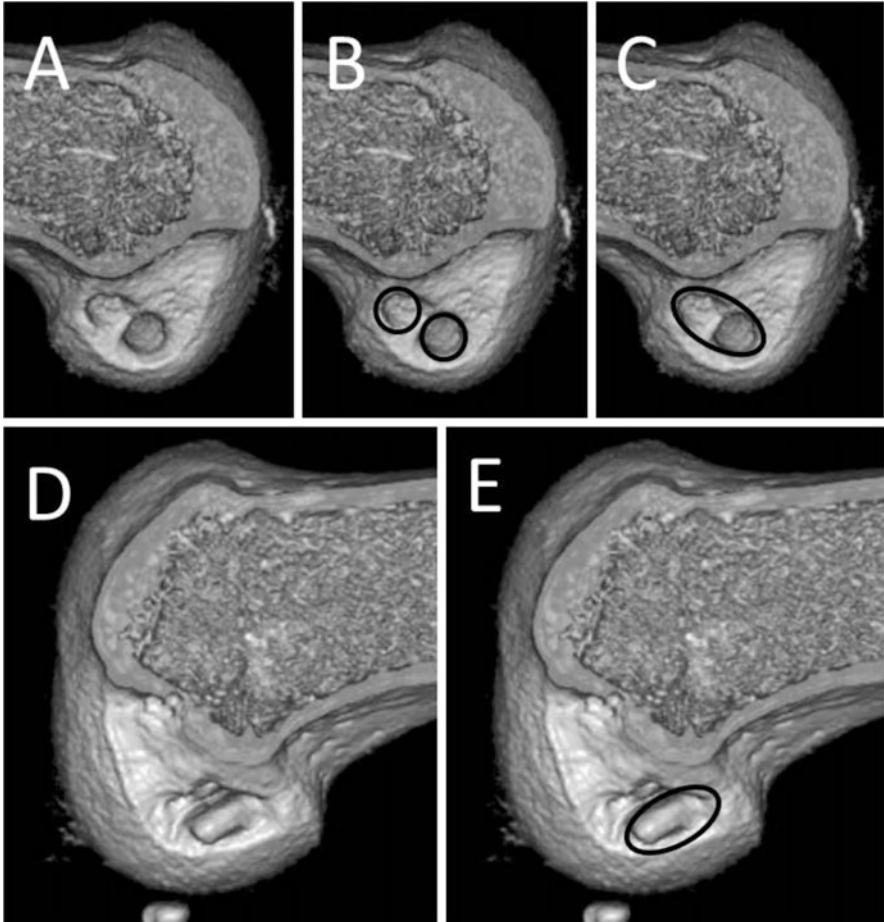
(a–c) Preoperative three-dimensional (3D) computed tomography (CT) images of the *left knee* demonstrating anatomical positioned femoral tunnels without tunnel widening. (b) Two anatomical tunnels in a revision procedure using hamstring tendon grafts are marked. The previous tunnels can be used. (c) The *black ellipse* shows anatomical rectangular tunnel position in a revision procedure with bone-patellar tendon-bone (BPTB) graft by dilating the previous two previous tunnels. (d, e) Preoperative 3D CT images of the *right knee* demonstrating an anatomical positioned femoral rectangular tunnel without tunnel widening. (e) The *black ellipse* shows a new anatomical rectangular tunnel in a revision procedure with a BPTB graft
